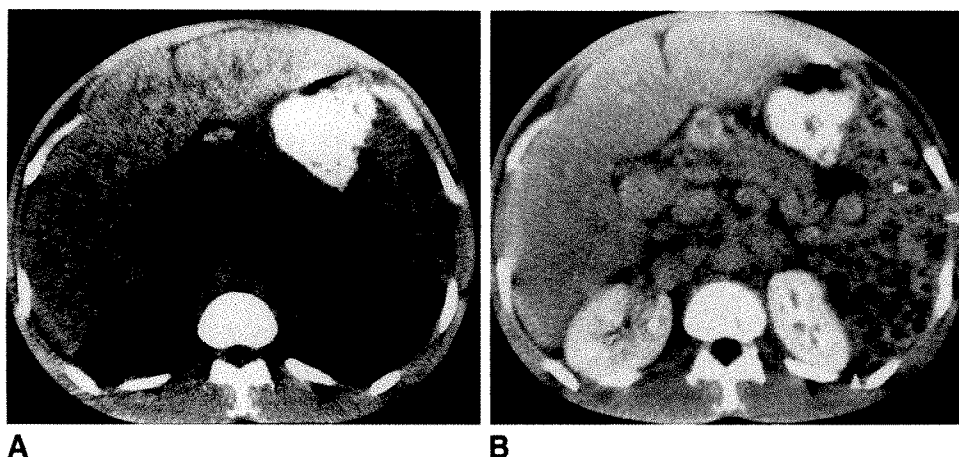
A, Unenhanced CT scan shows hypodense nodules in liver and spleen and enlarged retroperitoneal lymph nodes.
